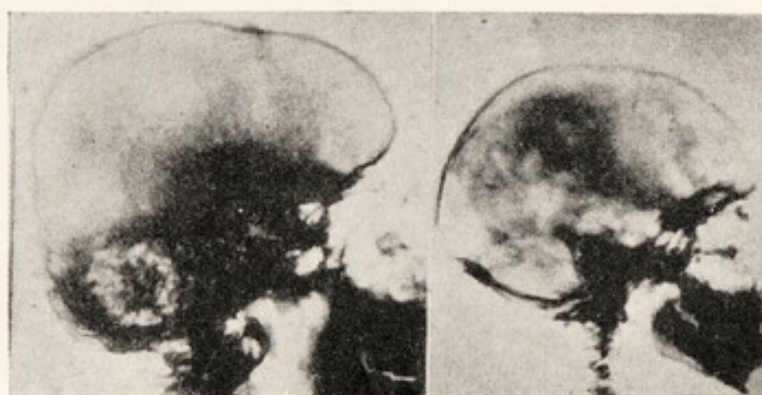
X-ray photograph of skull of patient (Fig. 46) at age of eleven, compared with that of a normal boy of the same age. There is an extraordinary development of the mastoid air cells. The sella turcica measured 2.5 cm. anterior-posteriorly; it has been outlined with dots to indicate its extent. (From Behrens and Barr, *ibid.*, p. 122.)
